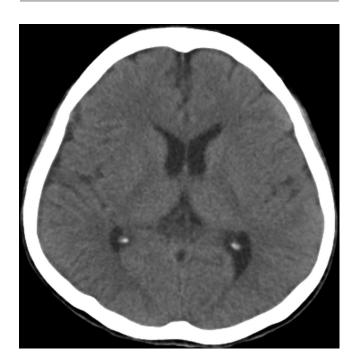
Noncontrast axial computed tomography at the initial presentation showing the lateral ventricles with intact appearance.
